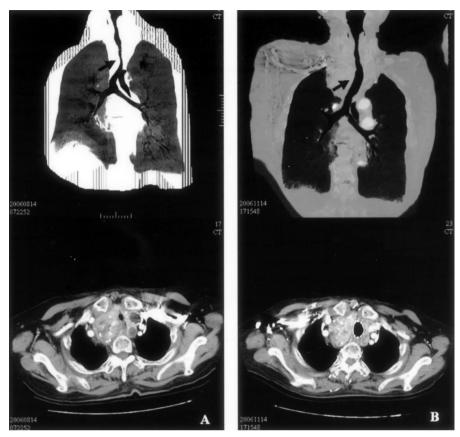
A. Neck and chest computed tomography (CT) revealed right-side thyroid enlargement with external compression of the trachea and induced tracheal lumen narrowing; B. Three months after interventional bronchoscopy with stent implantation, follow-up CT showed the previous tracheal narrowing had improved with the stent.
